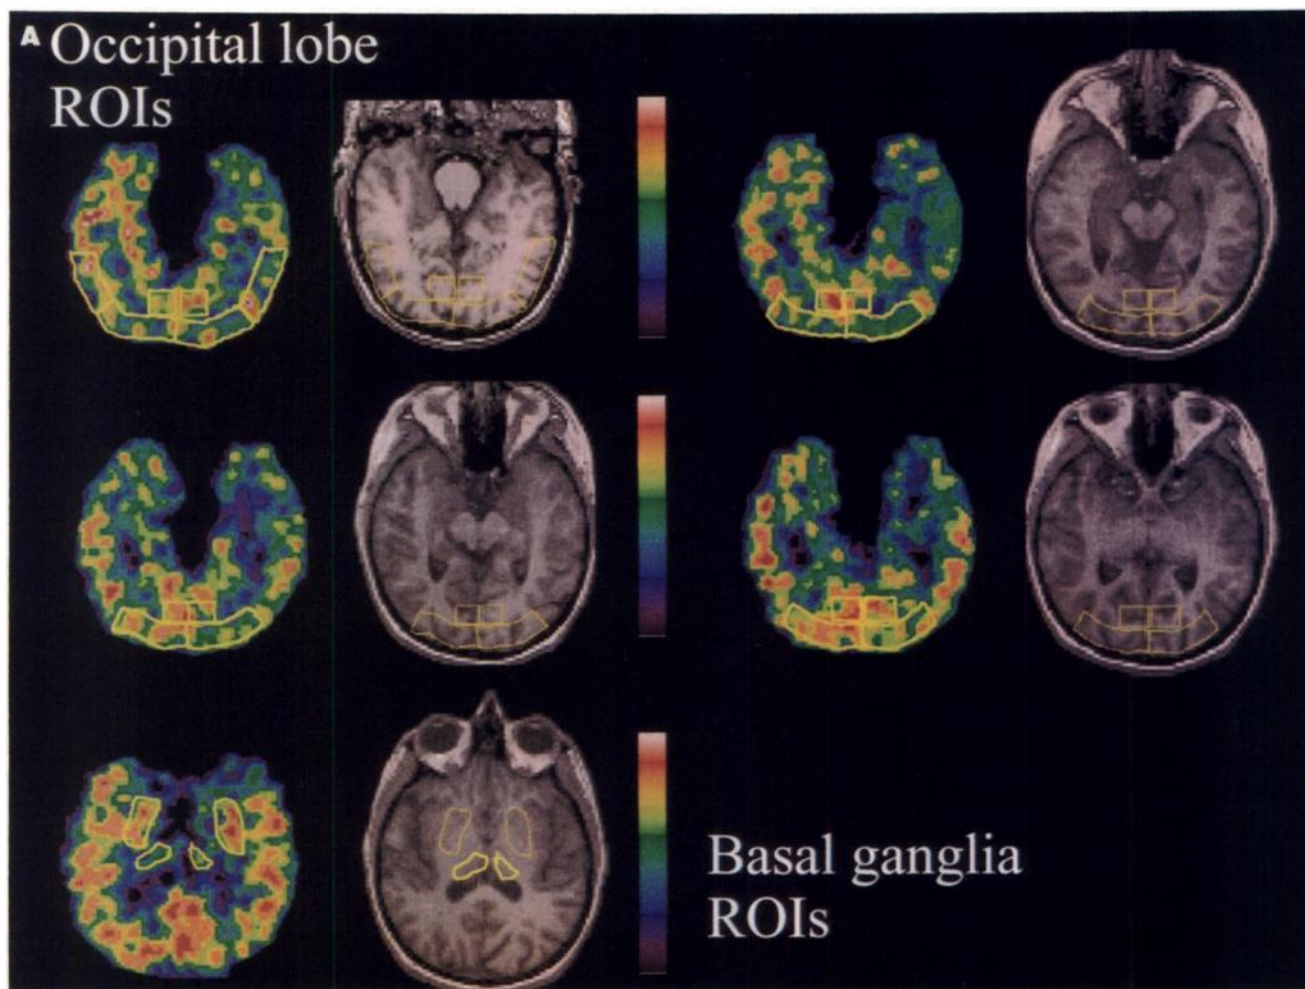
PET representation of regions of interest (ROIs) with MRI correspondence. (A) Occipital lobe and basal ganglia ROIs.
